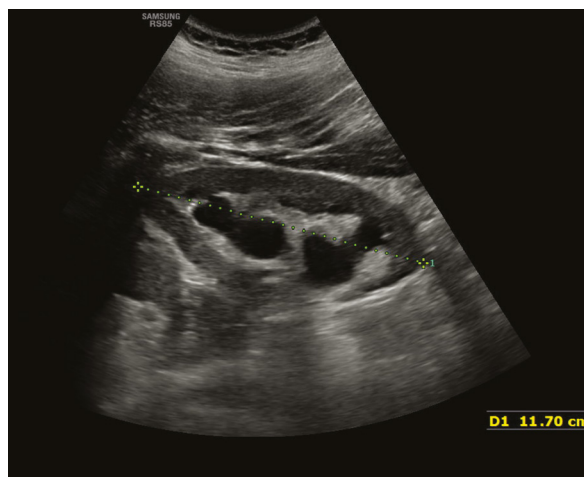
Ultrasound after the last retrograde intrarenal surgery in the described patient
